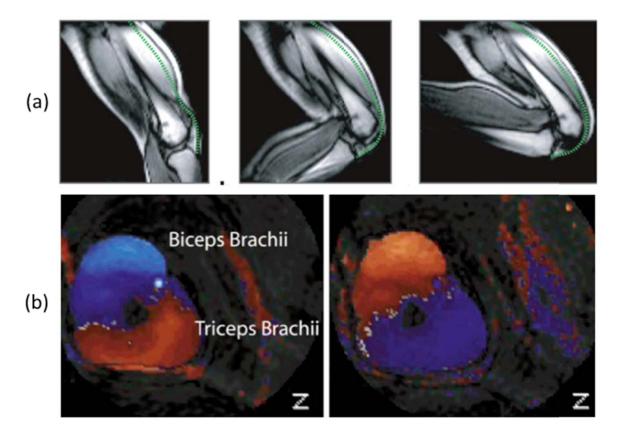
Common functional properties of skeletal muscle derived from advanced medical imaging techniques: dynamic MRI for muscle moment arm (a) and real-time cine phase contrast MRI for muscle contraction velocity (b) (adapted from [ASA 03] and [BLE 07]).
